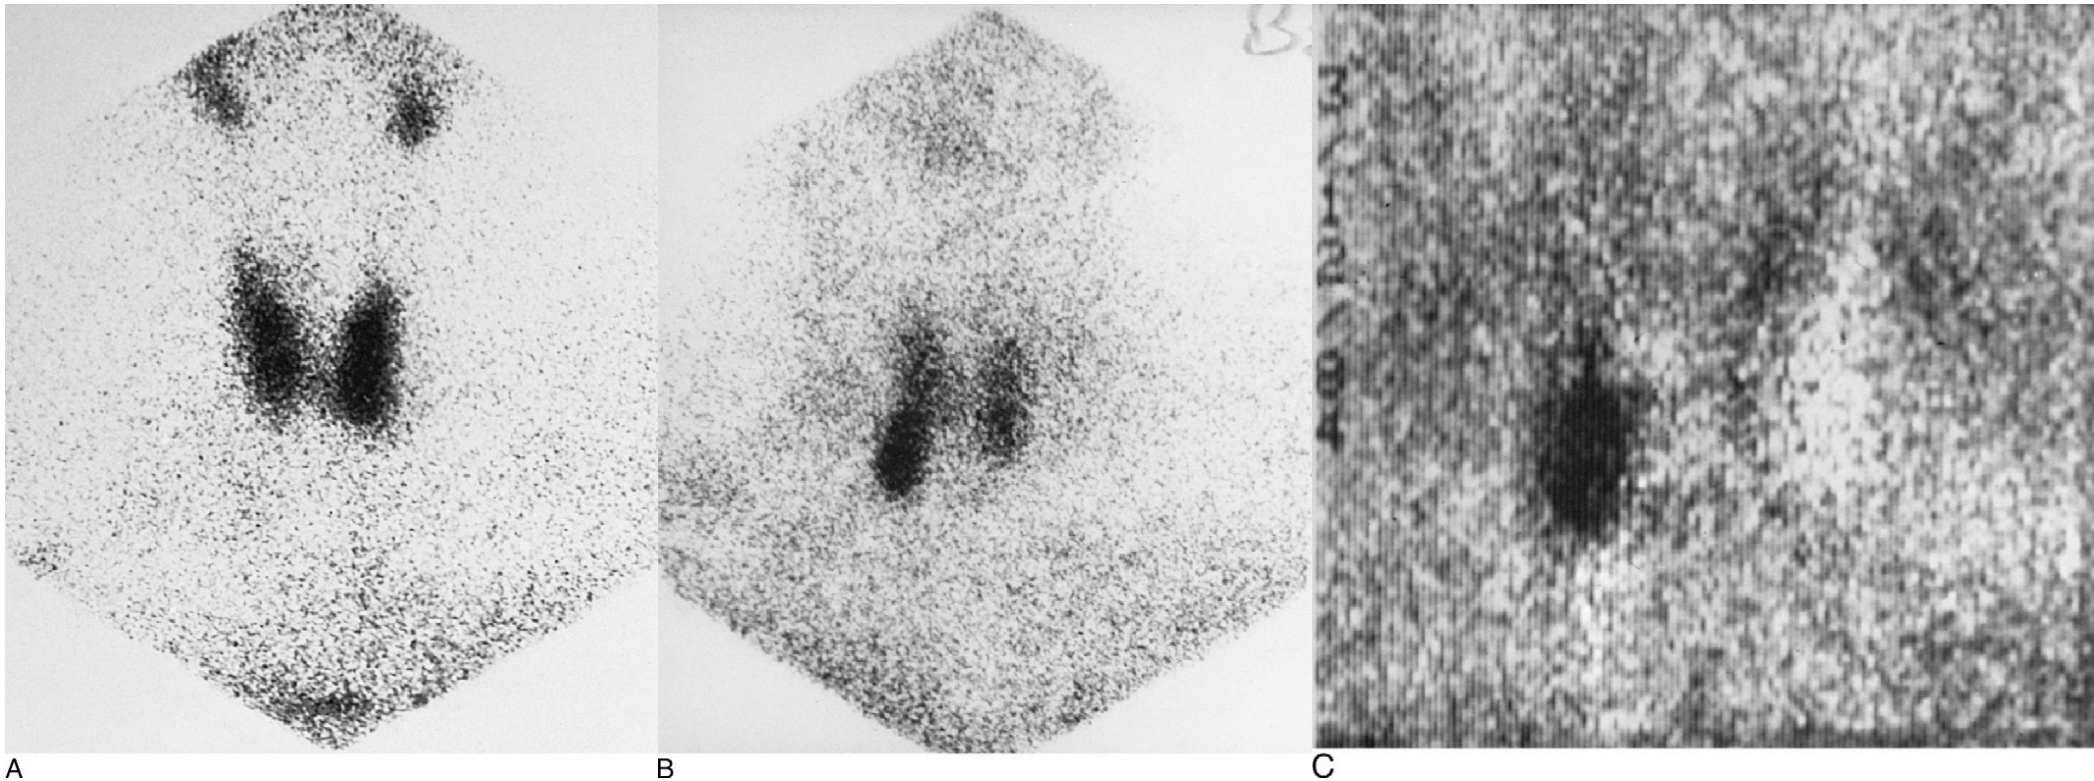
Thallium-21/Tc-99m pertechnetate parathyroid subtraction scan. Patient has hypercalcemia and increased serum parathormone level. A, Tc-99m pertechnetate scintigraphy in a patient is essentially normal. B, Corresponding Tl-201 scintigraphy reveals an apparent area of increased uptake adjacent to the lower pole of the right lobe. C, Subtraction of the Tc-99m pertechnetate study from the Tl-201 study confirms the presence of the parathyroid adenoma.
